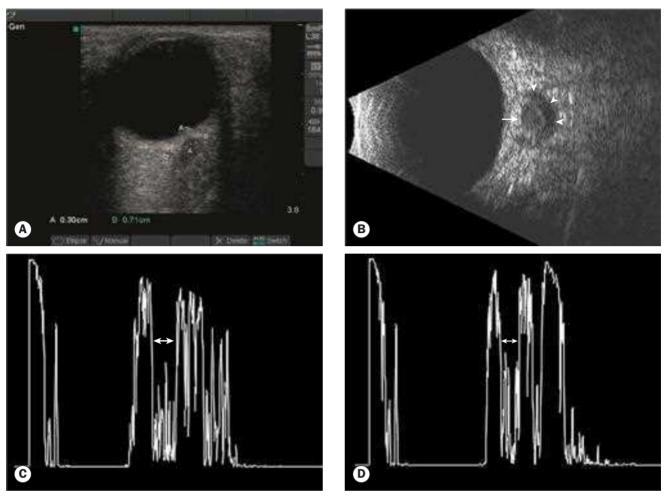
Ultrasonography in papilloedema. (A) Optic nerve sheath diameter of 7.1 mm, 3 mm posterior to the globe; (B) transverse B-scan showing crescent sign (arrow heads); optic nerve sheath diameter is measured 3 mm behind the globe (arrow); (C) A-scan in primary position with retrobulbar nerve diameter of 4.8 mm; (D) in lateral gaze diameter reduces to 3.5 mm – positive 30° test
